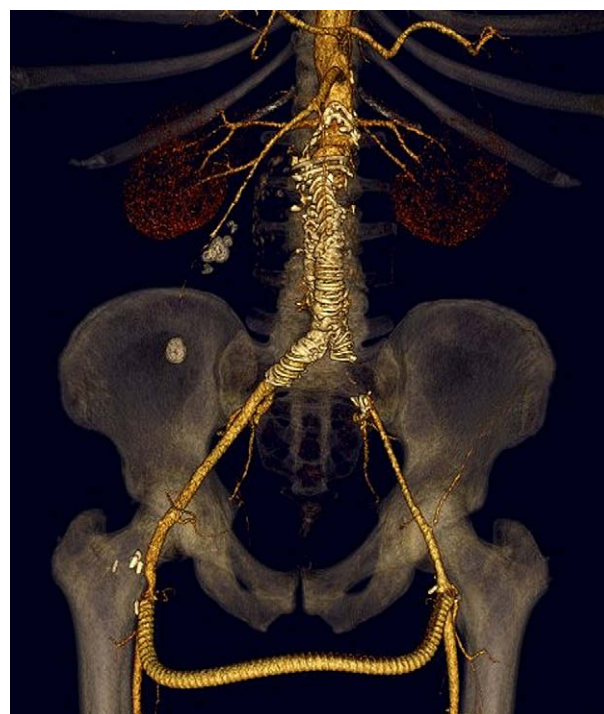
Follow up CT scan reconstruction: No leaks were observed. The femoro-femoral crossover by-pass is patent and both hypogastric arteries are preserved.
